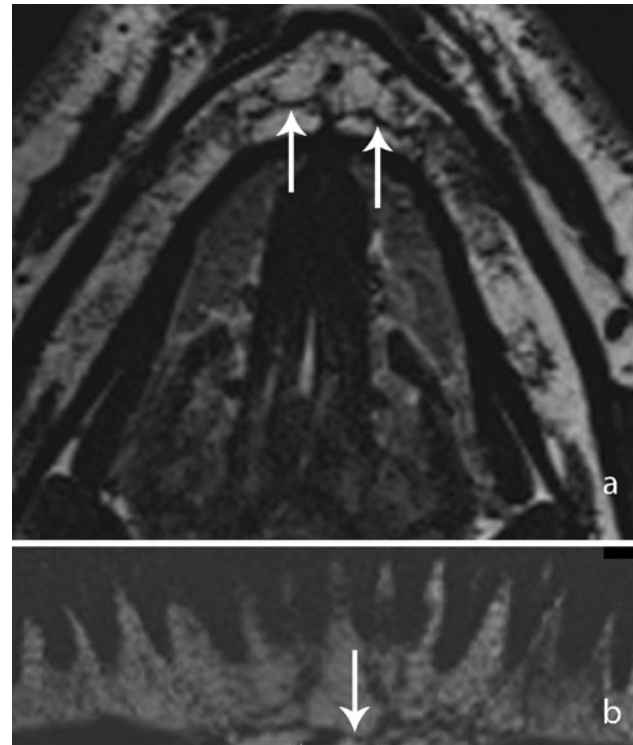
Axial (a) and panorama-reconstructed (b) T2-weighted images of the anterior chin region. Anastomosis of the incisive canal (arrows)
